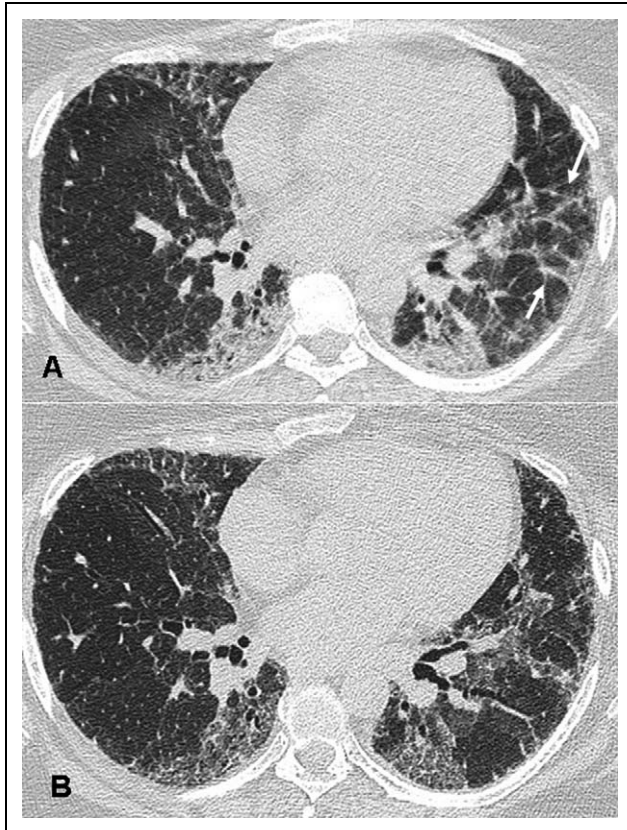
CT of a 54-year-old woman with polymyositis showing; A – patchy consolidation and peribronchovascular pattern (arrows); B – four months later, following start of immunosuppressive treatment, the consolidation has been replaced by fine reticulation and distortion, in keeping with established fibrosis. The peribronchovascular pattern in the left lung has resolved. This evolution is consistent with fibrosing organizing pneumonia.
